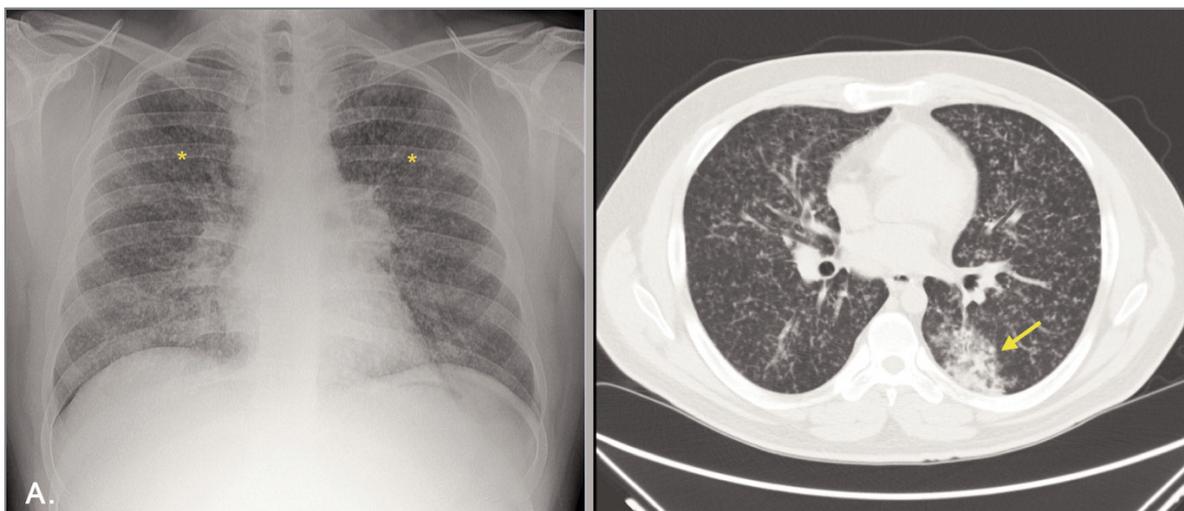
Case 1 patient A. PA chest x-rays demonstrate wide spread small nodular opacities distributed throughout both lungs (*); B. Best CT showed dispersed micronodular pattern, with presence of small consolidation in air bronchogram in the upper segment of the left lower lobe (arrow)
